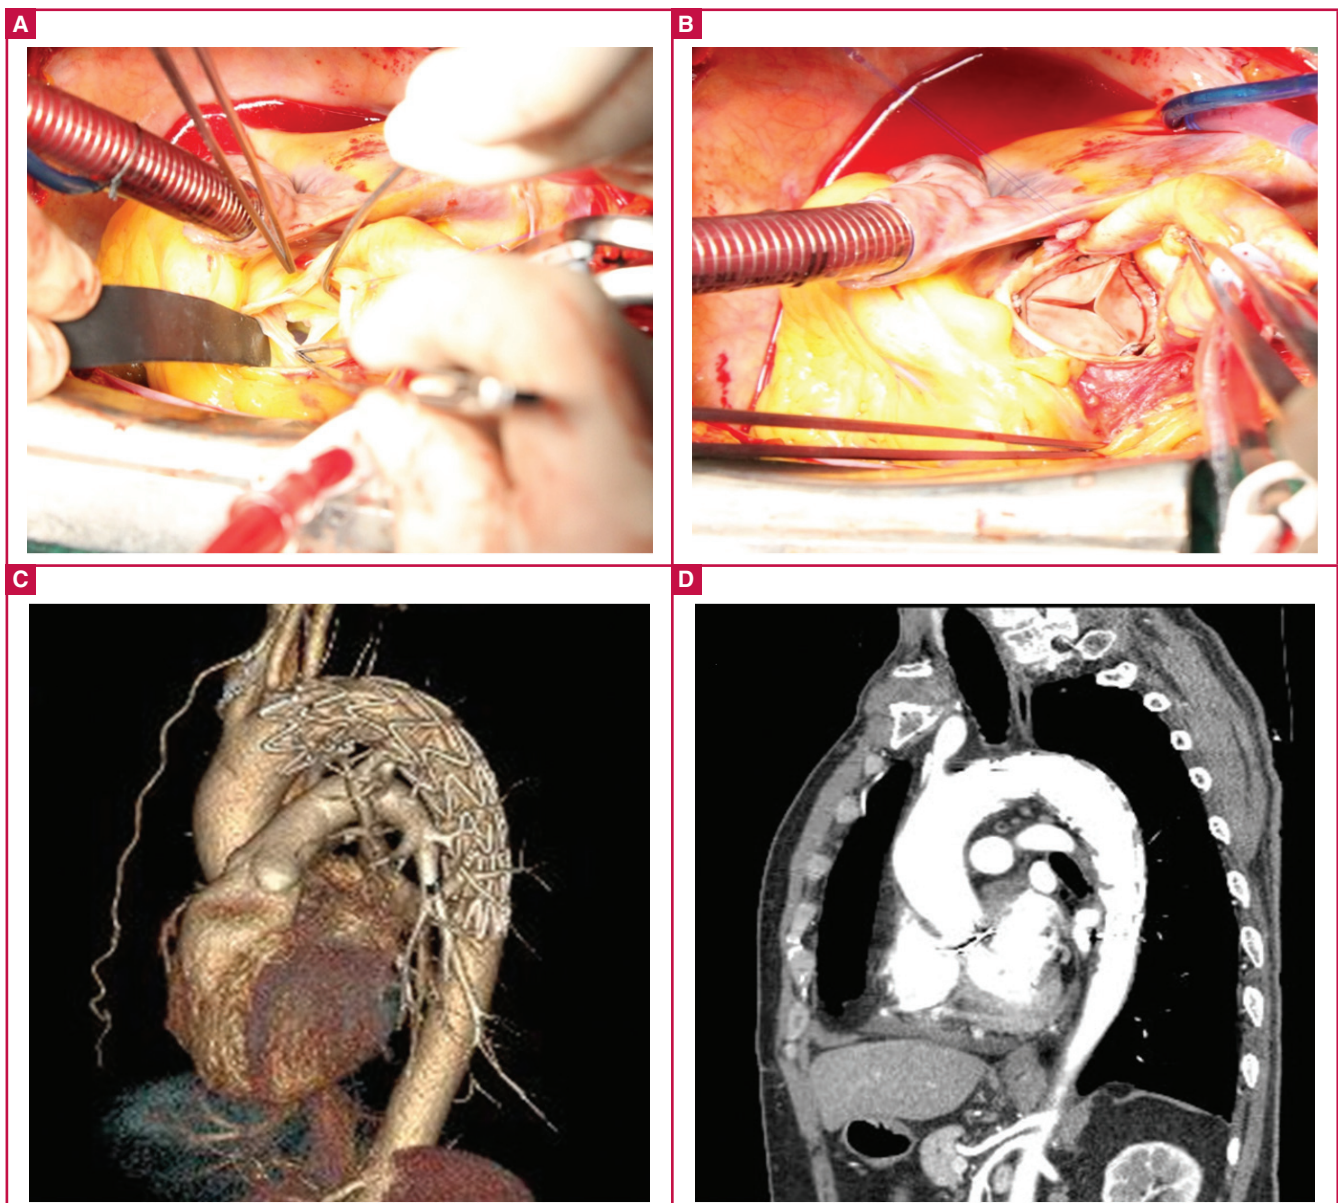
Intra-operative photographs of the aortic valve, and CT angiographic findings after implantation of a stent graft. (A) Perforation of the non-coronary cusp of the aortic valve is seen. (B) The aortic valve was removed and replaced with a bioprosthetic valve. (C) and (D) The pseudo-aneurysm was not seen after stent graft implantation in reconstructed CT images.
